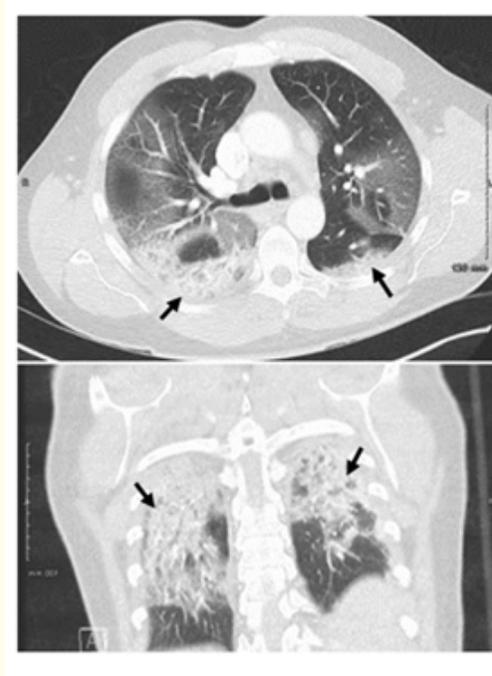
CT Thorax showing bilateral ground glass changes and consolidation.
